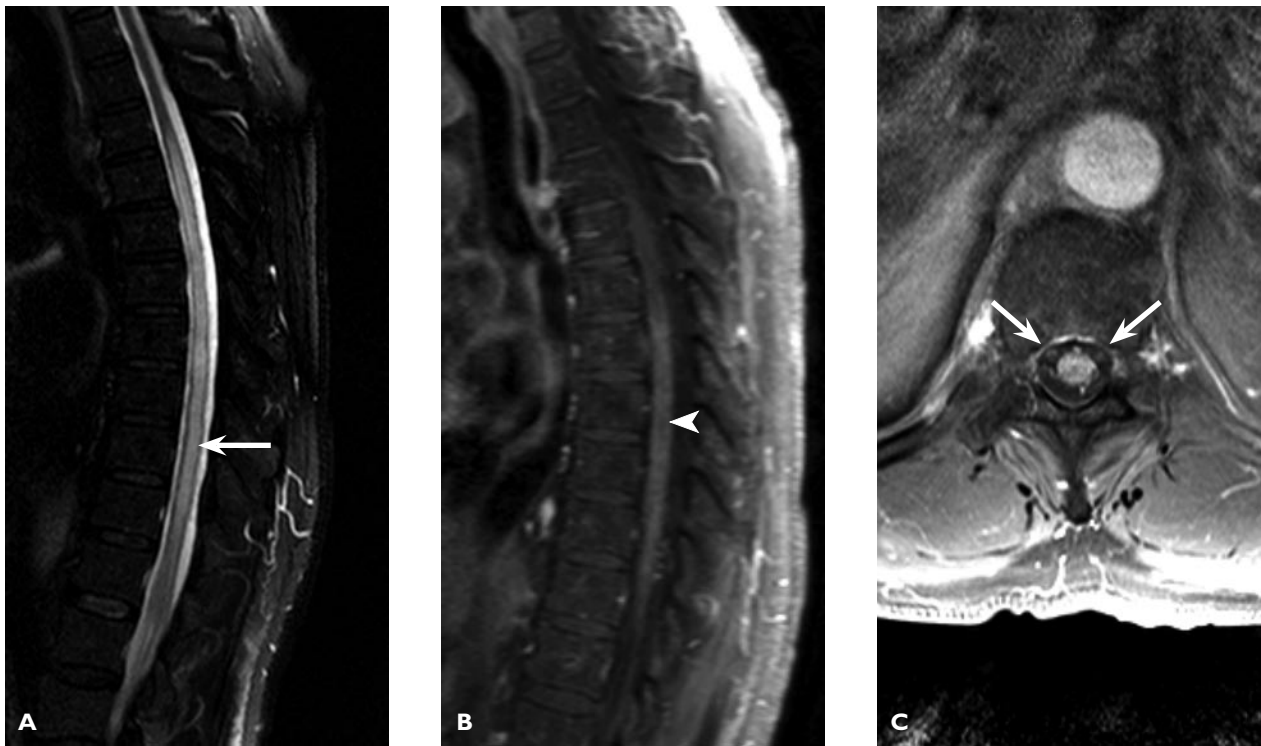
A T2-weighted magnetic resonance image (A) of the thoracic and lumbar spine demonstrated a hyperintense intramedullary lesion with cord edema extending from T4 to the conus (arrow). After gadolinium administration, a T1-weighted magnetic resonance image (B) demonstrated this lesion enhancing diffusely (arrowhead). Magnetic resonance angiography (C) revealed several minimally dilated vessels that were considered normal (arrows).
